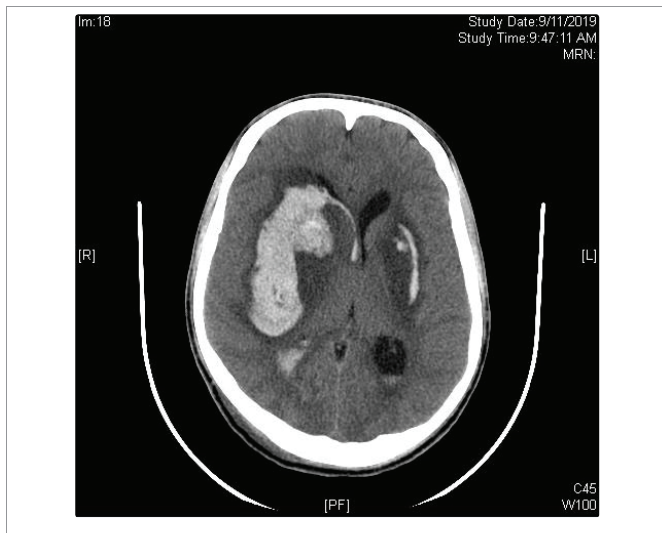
Follow up CT brain on day 4: Bilateral hemorrhagic transformation more on right side with mass effect.
